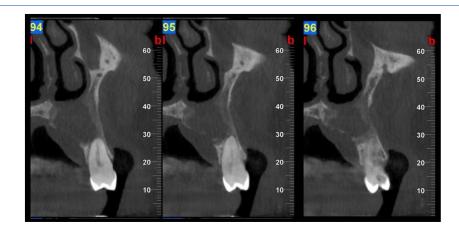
(Post-operative CBCT images (2 months after the surgery).)
